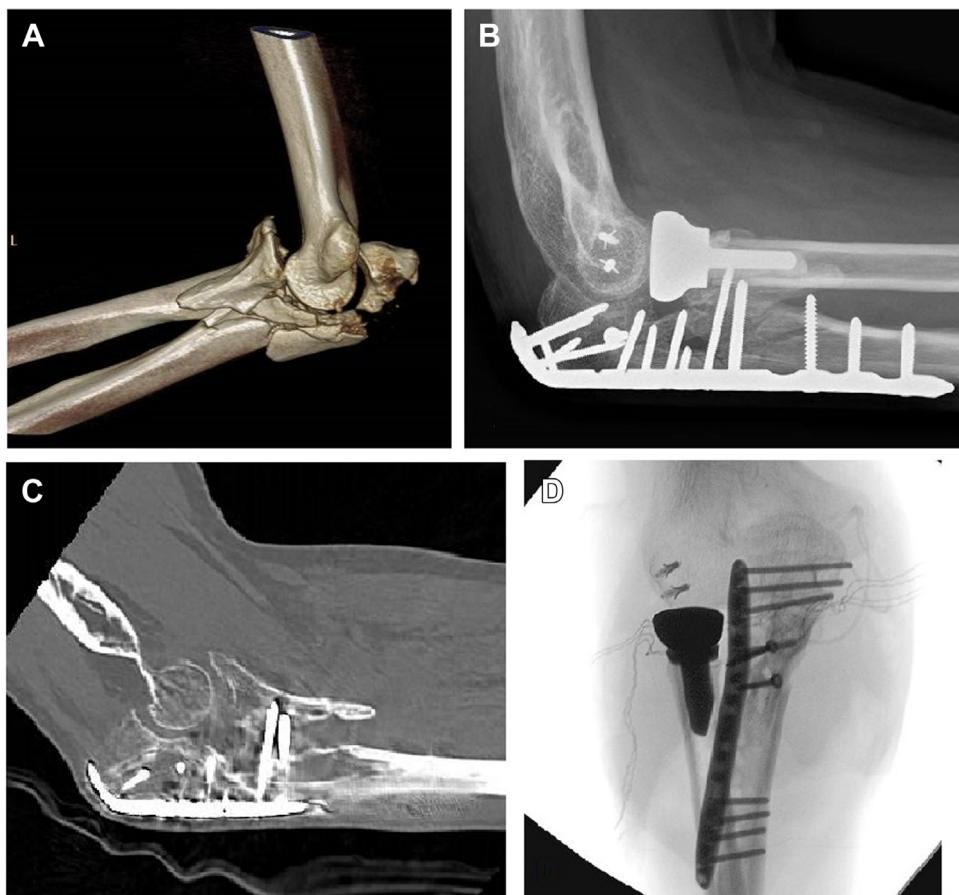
3D reconstruction of a CT scan of the Right elbow of a 54-year-old male with a transolecranon elbow dislocation with a comminuted olecranon fracture extending in the coronoid and a comminuted radial head fracture (A). The patient was initially treated in a local hospital with plate fixation of the olecranon, radial head replacement, and LCL refixation (B). After five months, the patient was referred to an elbow expertise Center with complaints of persistent pain and decreased range of motion. Physical examination demonstrated persistent instability and subluxation of the elbow. A CT scan showed nonunion of the large coronoid fragment (C). The patient was treated with an extended arthrolysis by a posterior approach. A revision of the radial head replacement was performed because of loosening. The olecranon plate was removed, and the coronoid fracture was reduced and fixed with two lag screws. The olecranon was incompletely healed and fixed again with plate osteosynthesis (D). CT, computed tomography; LCL, lateral collateral ligament.
